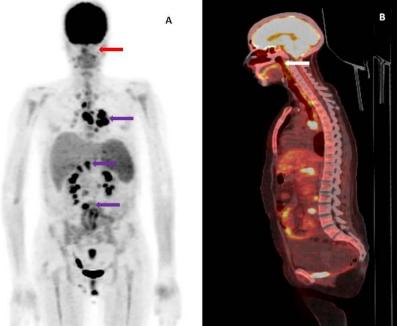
18-FDG PET scan of treatment evaluation after five courses and external radiotherapy (MIP on the left and sagittal section on the right) showing the disappearance of the previously described hypermetabolic focus at the level of the cavum tumor process, but the appearance of new supra- and subdiaphragmatic lymph node involvement
